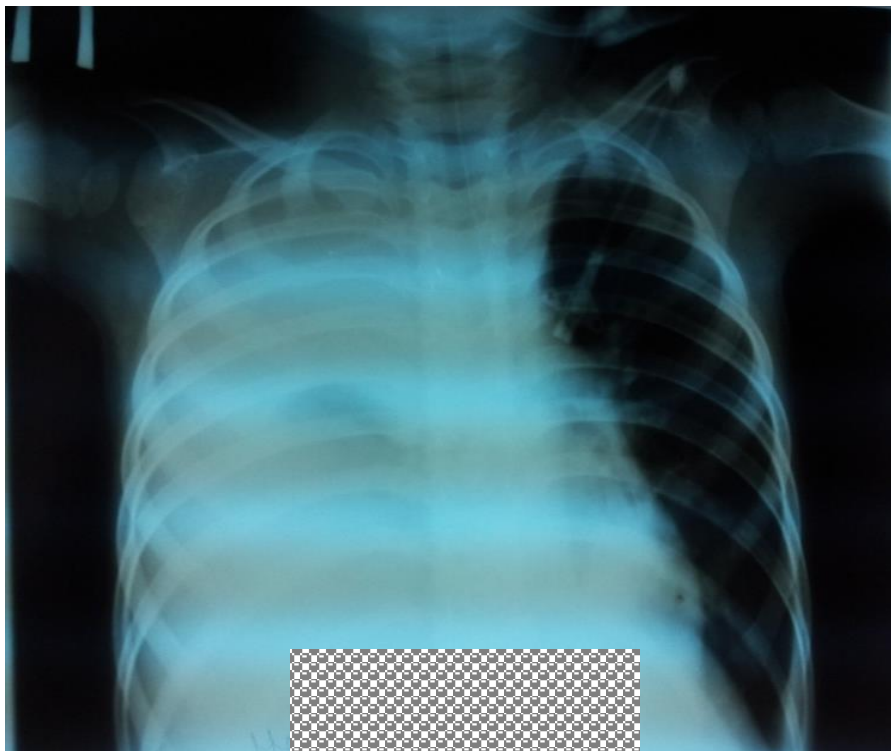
X-ray of the chest.
